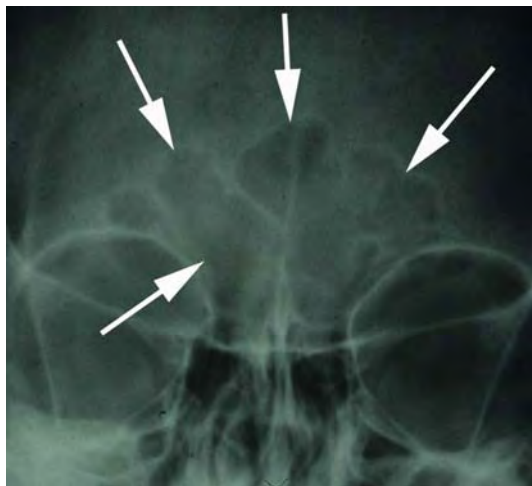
A skull X-ray, showing the unique shape of the frontal sinuses, which represent radiolucent (*darker*) air pockets within the skull of the forehead (*arrows*)
